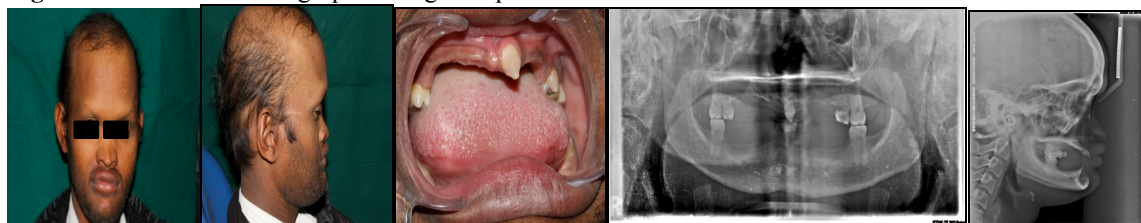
Clinical and radiographic images of patient's sibling
